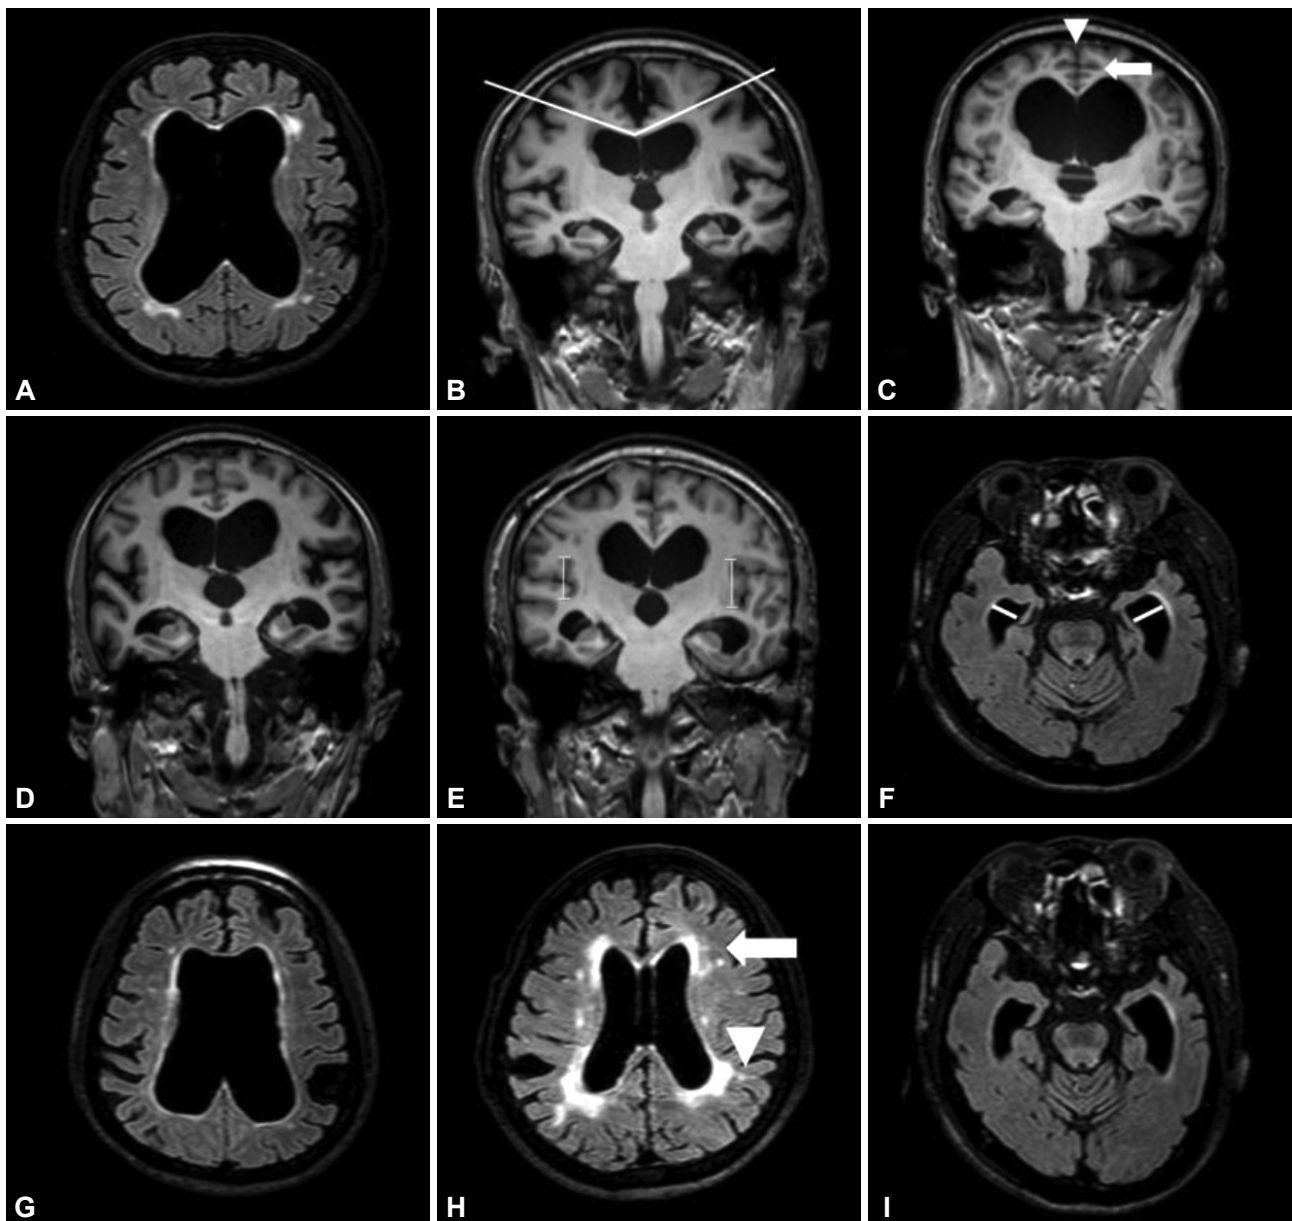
MRI parameters. A: EI. B: Degrees of the callosal angle. C: Narrowing of the superior parietal sulci, graded as 2=vertex. D: Height of the Sylvian fissure. E: Width of the temporal horn. F: Perihippocampal fissure dilatation, graded as 2=severe. G: Focally enlarged cerebral sulci, graded as 1=present. H: Periventricular hyperintensities, graded as 3=confluent areas. I: MTA scale, graded as 2.
